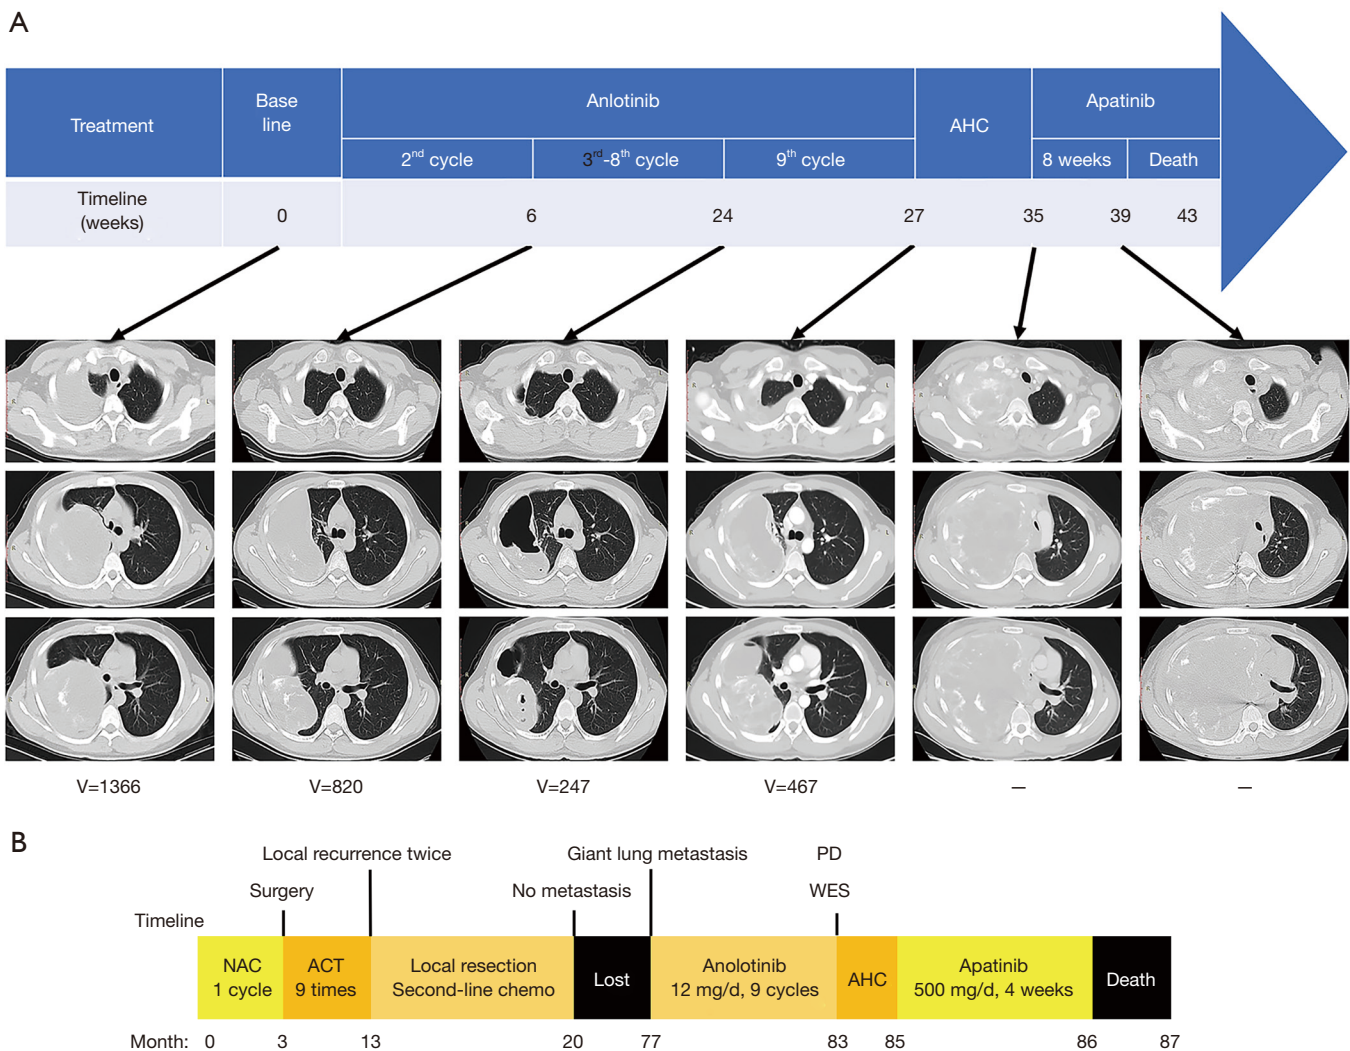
Therapeutic process of the patient. (A) CT imaging showed a shrinkage of tumor volume compared with the baseline at 2 and 6 months after anlotinib administration; PD at 7 and 9 months; SD at 10 months. (B) The various treatments the patients received as well as the duration of each treatment. NAC, neoadjuvant chemotherapy. ACT, adjuvant chemotherapy. PD, progression disease. WES, whole exome sequencing; AHC, argon-helium cryoablation.
